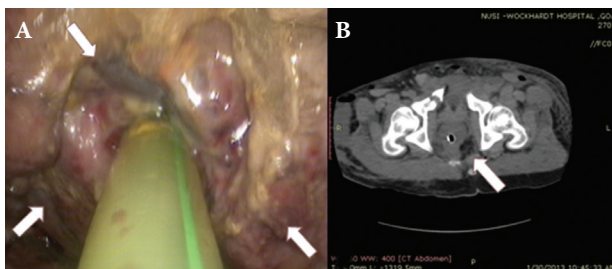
(A) Intracavity photograph of avulsed anorectal stump, part of skin avulsed seen attached to anal canal (top arrow), surrounded by the anal sphincter and puborectal muscle with exposed levator ani both sides (both lower arrows). (B) Corresponding plain CT scan abdomen horizontal section demonstrating avulsed anorectal stump separated from the sacrum
